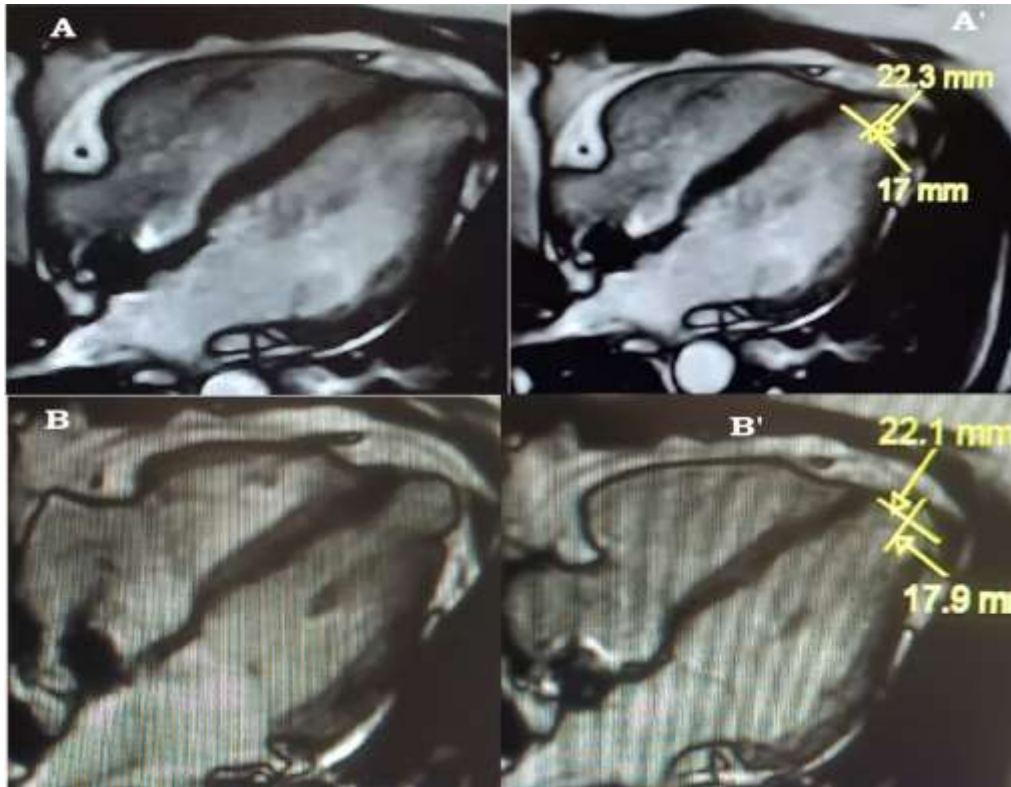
Left ventricle apical congenital diverticulum on myocardial MRI on apical 4 chambers view in systole (A and A'); diastole (B and B'); measuring 22.3mm*17mm (A') and 22.1mm*17.9mm (B').
